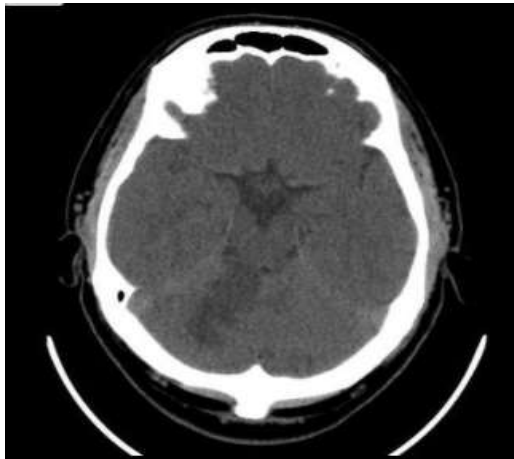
A 67 year old male patient known with HTN, dyslipidemia, DM and obese, with postoperative right hemi-ataxia and truncal ataxia, CT showed right cerebellar infarction.
